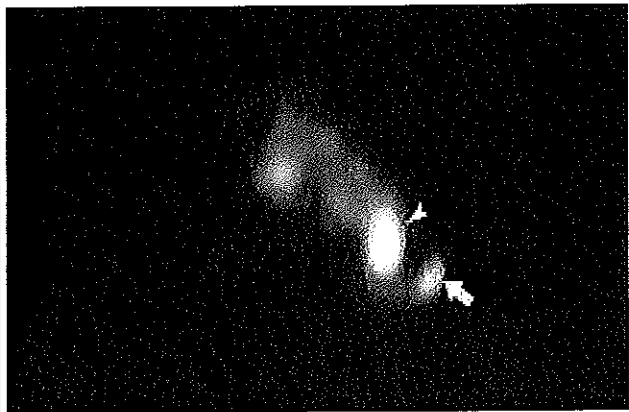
Normal increased FDG uptake in the shoulder area which represents brown fat.
